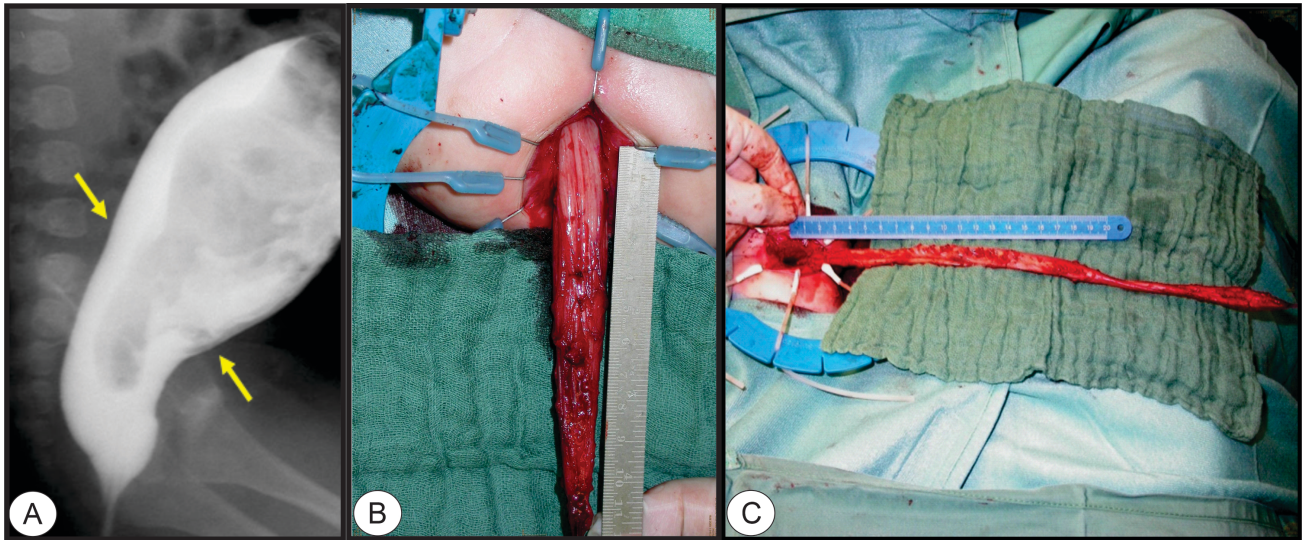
De la Torre's procedure for aganglionosis (Hirschsprung's disease). According to de la Torre, four steps are critical, including (1) spreading the anal canal, exposing the dentate line and making a circular incision of the rectal mucosa approximately 1 cm orally from it and attaching sutures; (2) sheathing the rectal mucosa; (3) opening the peritoneal fold and mobilizing the sigmoid colon, and (4) taking extramucosal biopsies for determination of the resection limit. In (A) is the X-Ray-imaging of the transition zone between aganglionosis of the rectum and ganglionosis (euganglionic segment) of the sigmoid colon (arrows). In (B) is shown the operation site of the transanal endorectal rectosigmoidectomy and in (C) is shown the recto-descendectomy performed according to de la Torre. The surgical site gross photographs and X-ray photographs belong to the personal archive of Professor Dr. J. Hager. Written informed consent was provided by the parents/guardians at the time of the surgical procedure.
